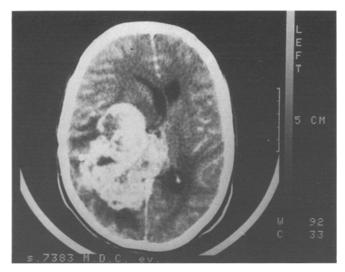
CT scan of the brain showing a large mass in the right temporo-occipital region. The neoplasm displaces the ventricular system. Case 2
